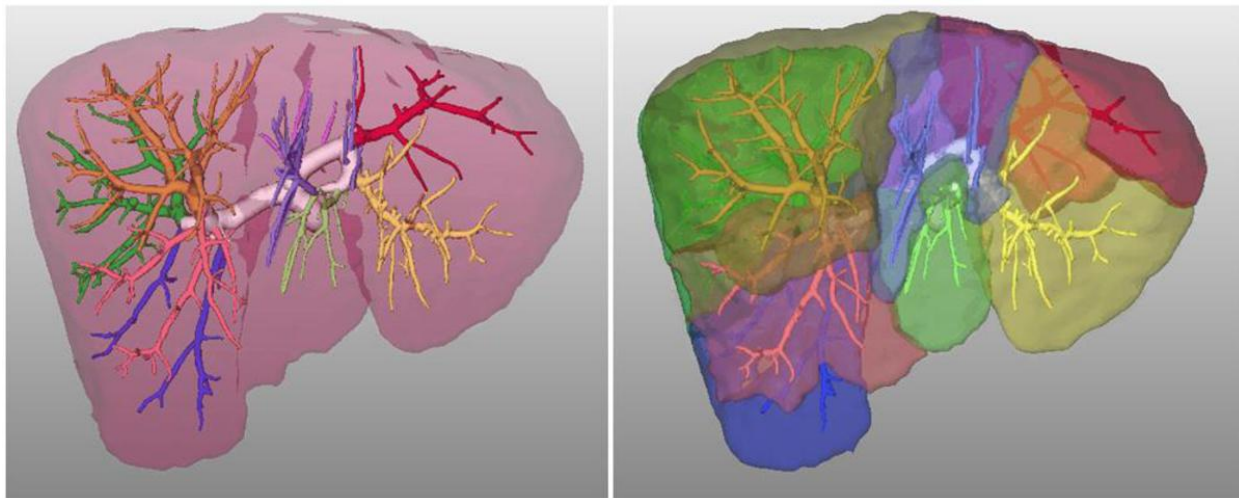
Hepatic segmental anatomy. Frontal views of color-coded three-dimensional CT images from a liver donor show the various portal ramifications and corresponding liver segments.
